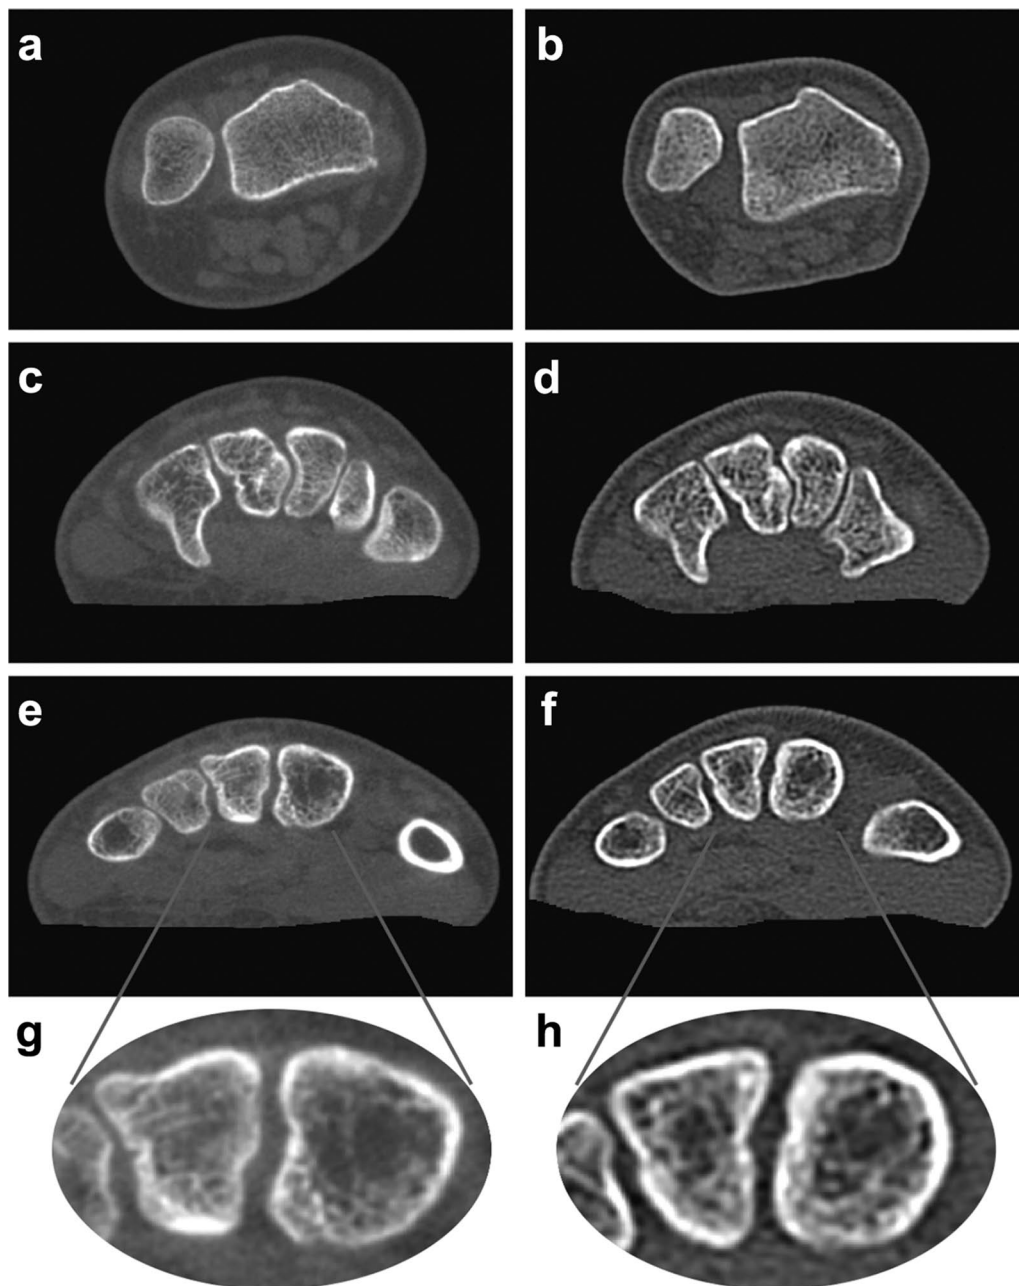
Bone imaging in cone-beam CT and multidetector CT. The figure shows axial CT reconstructions at the level of the distal forearm (a, b), carpus (c, d) and metacarpus (e, f). The reconstructions are from two different patients, one examined by cone-beam CT (a, c, e), the other by multidetector CT (b, d, f). Magnification views of the metacarpal bones are attached to better appreciate the differences in the representation of the bone structure (g, h). *CT* computed tomography
